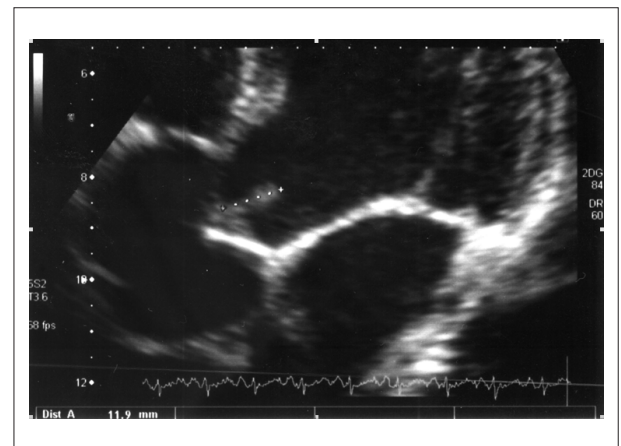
Transthoracic echocardiography showing a thickened aortic valve with a mobile, echogenic structure measuring 11 cm in its largest diameter. .
